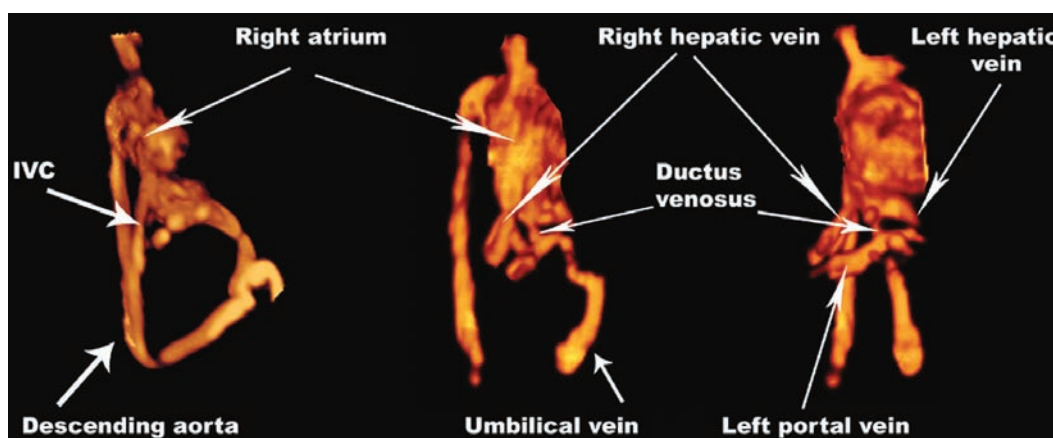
This is a 3D power Doppler rendered volume of the fetal cardiovascular system of a normal 23-week-gestation fetus. This volume has been rendered only with the 3D power Doppler without the presence of any gray-scale information. As this is the volume data, it can be rotated to depict different views of the anatomy. Note the detailed visualization of the descending aorta, inferior vena cava (IVC), right atrium, umbilical vein, right hepatic and left veins, left portal vein and ductus venosus.
